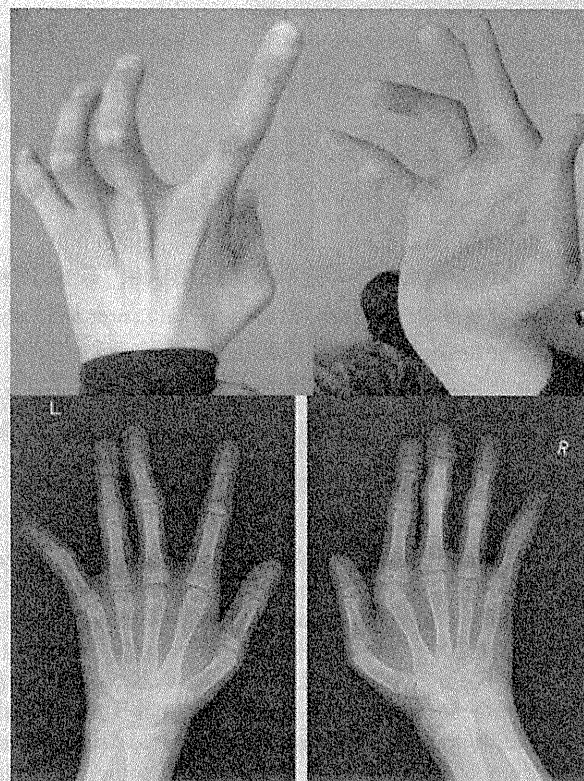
A: Hands of the patient showing camptodactyly of middle and ring fingers, inflexible distal interphalangeal joints of index fingers and adducted thumbs of both hands. B: Radiograph of the hands. The proximal interphalangeal joints of both middle and ring fingers show flexion contracture with para-articular swelling.
